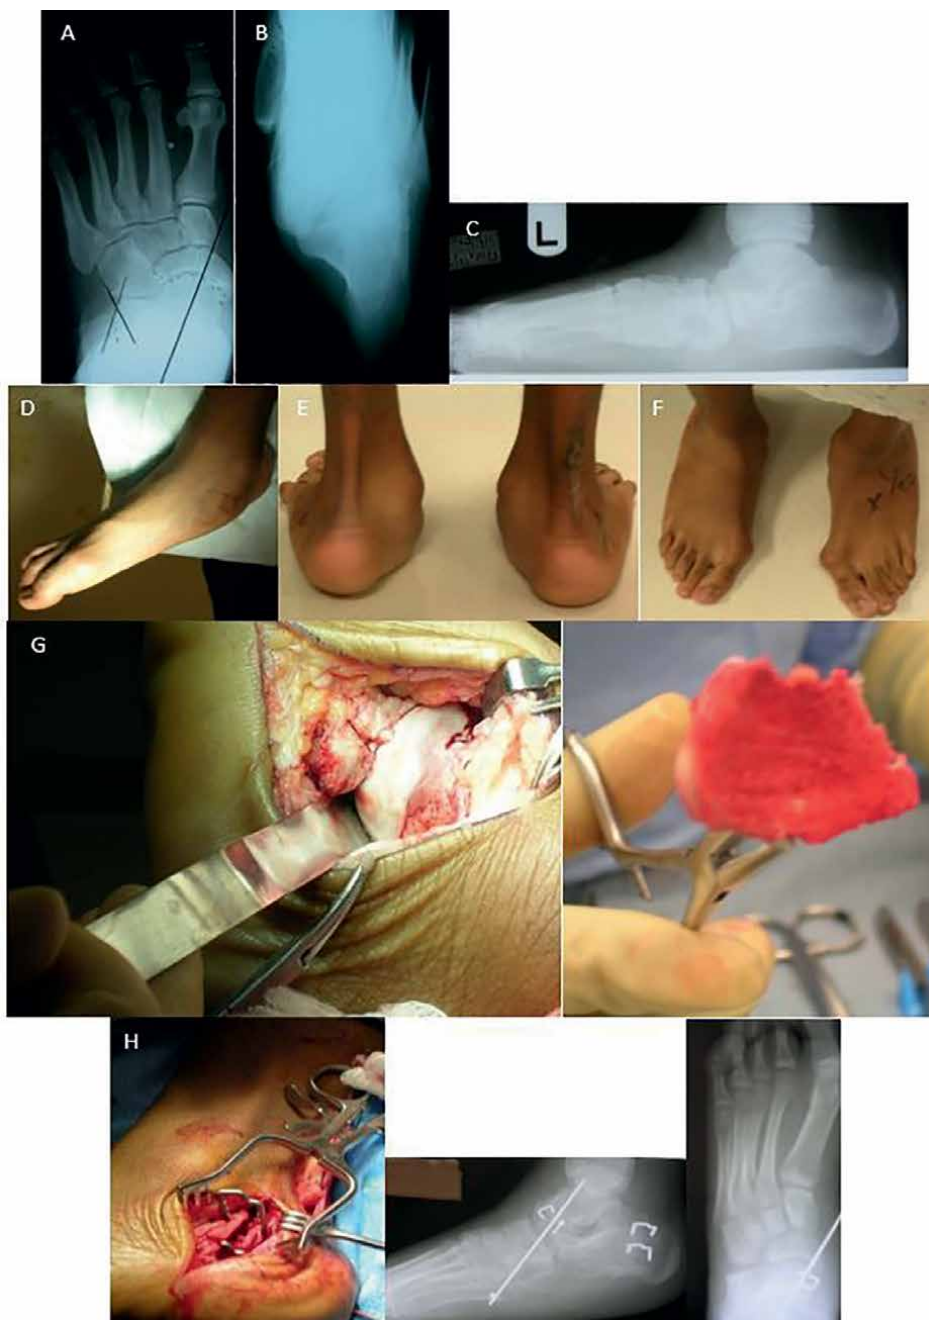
A: DP radiograph view of a left foot sagittal plane flatfoot; B: axial radiograph view of a sagittal plane flatfoot; C: lateral radiograph view of a left foot sagittal plane flatfoot; D: clinical photograph showing the lateral view of right sagittal plane flatfoot; E: clinical photograph showing the posterior view of sagittal plane flatfeet; F: clinical photograph showing the front view of sagittal plane flatfeet; G: surgical management of a sagittal plane flatfoot depicting sub-capital talar head wedge resection; H: proposed surgical management of a sagittal plane flatfoot with z-plasty of tendoachilles lengthening, Koutsogiannis calcaneal osteotomy.
